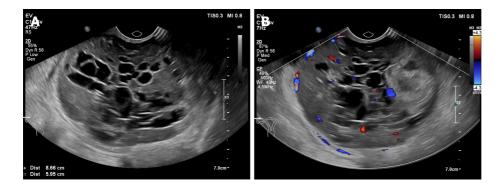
Ultrasound scan. A: An 87 mm × 60 mm mass with a heterogeneous echo is seen on the right side of the pelvic cavity. It consists of a hypoechoic intracystic effusion and a hypoechoic intracystic tumor, with local honeycomb changes; B: Color Doppler imaging shows hypervascularity.
